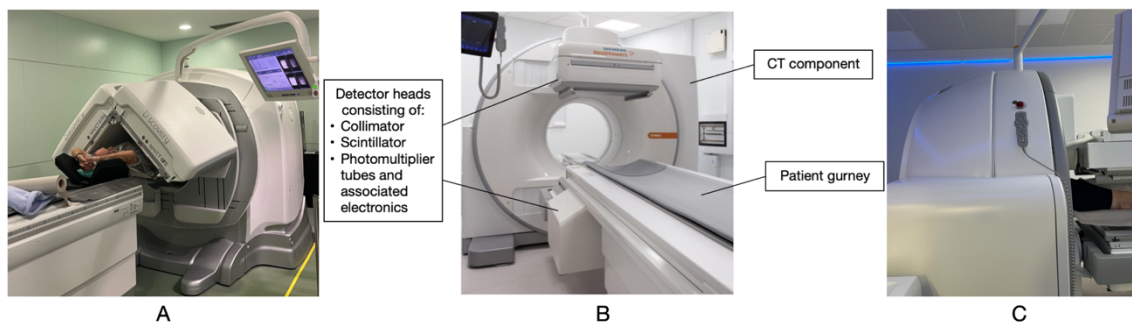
SPECT/CT machinery in our study. A. *Discovery NM/CT 670* SPECT/CT being used: the machinery surrounding the top of the patient (gamma camera) rotates to capture images in the diverse planes; B. front view of the *Siemens Symbia Pro* SPECT/CT with its components; C. *Siemens Symbia Pro* SPECT/CT (profile) to observe closeness of the detector heads to the patient (studied for breast cancer).
